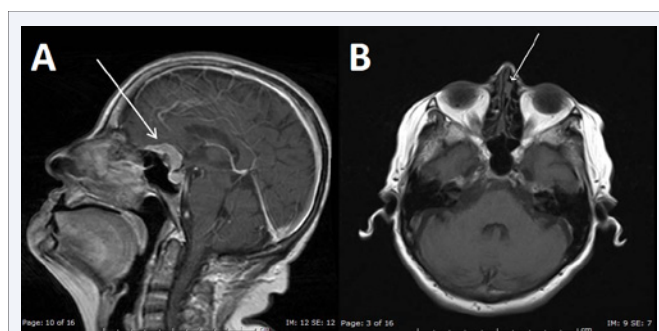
MRI Brain without contrast. (A) The arrow points to the suprasellar mass, measuring 3.0x2.3x1.4cm. (B) The arrow points to the left nasal mass, measuring about 1.1x1.1x0.5cm, which is initially missed by radiologists.
